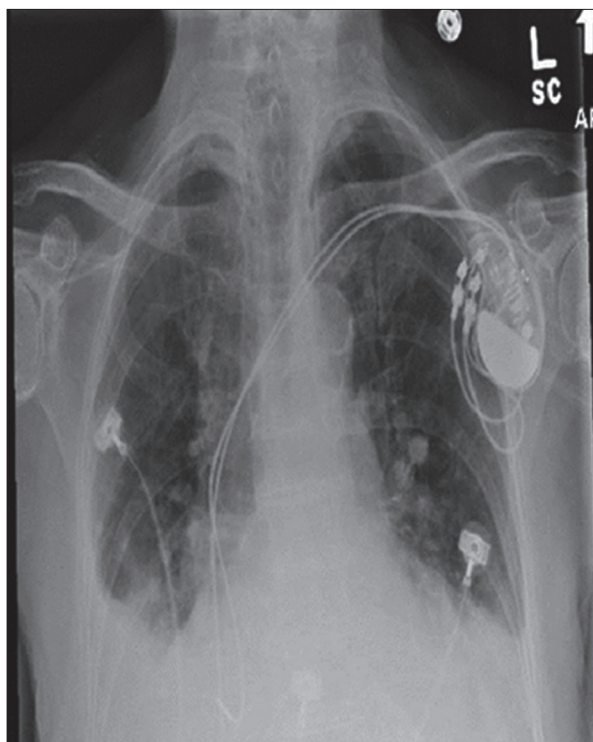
Chest X-ray of patient 1 three weeks after pacemaker implantation.
